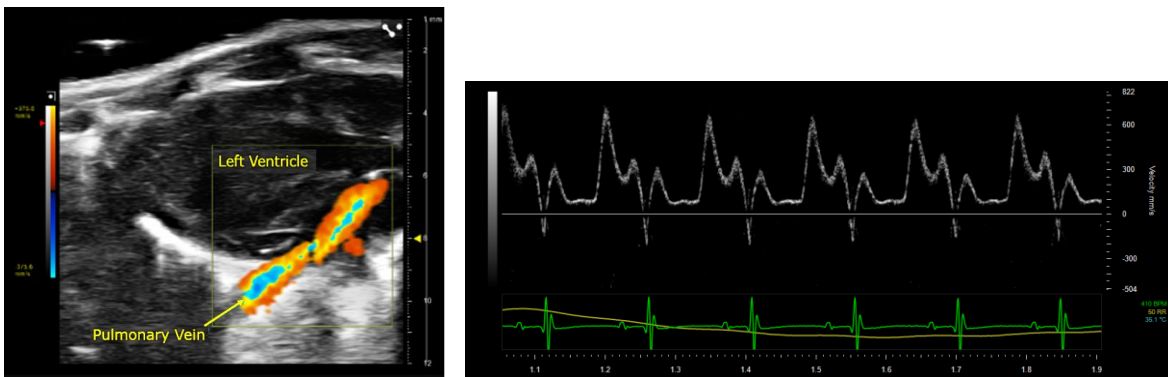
Pulmonary vein flow entering the left atrium shown using Color Doppler (left) and PW Doppler waveform of the PV (right).
